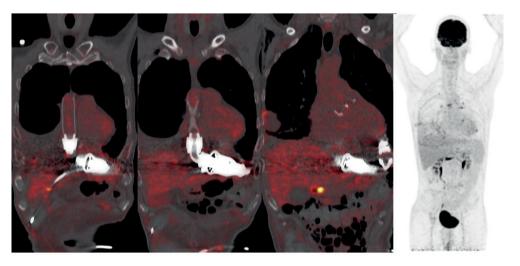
Case CII; 54-years-old male 24 days after LVAD exchange (678 days on support) PET/CT guided exclusion of active infection. Mild increased activity around the pleural fluid in the right lung, as well as slightly increased activity in multiple mediastinal and hilar lymph nodes bilaterally as well as in pleural nodular; all possible still reactive. There is no focus of infection. Other finding is subcutaneous emphysema with pneumothorax right sided.
